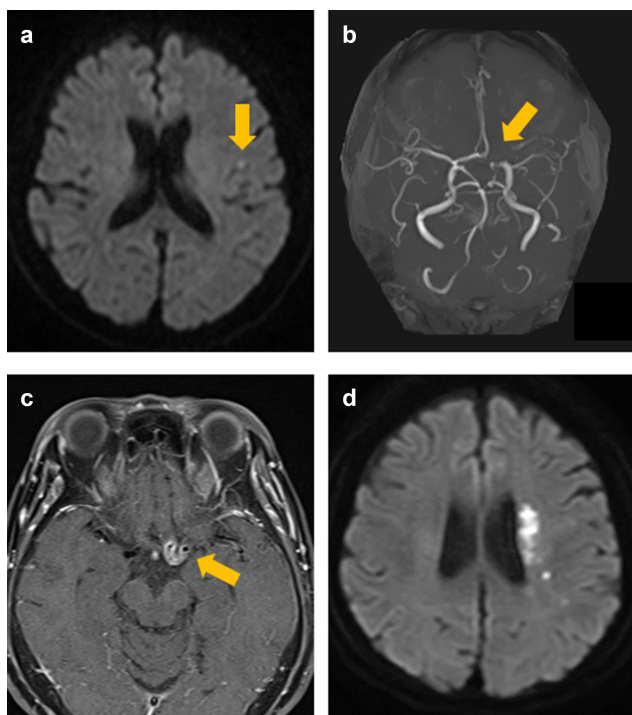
(a) Diffusion-weighted image (DWI), ischaemic lesion in the cerebral cortex of the left frontal lobe (Day 2); (b) MR angiography, severe stenosis from left internal carotid artery end to left MCA origin (Day 2); (c) contrast-enhanced T1-weighted image, augmentation effect corresponding to the vascular stenosis (Day 2); (d) DWI, the increase of ischaemic lesions (Day 7).
